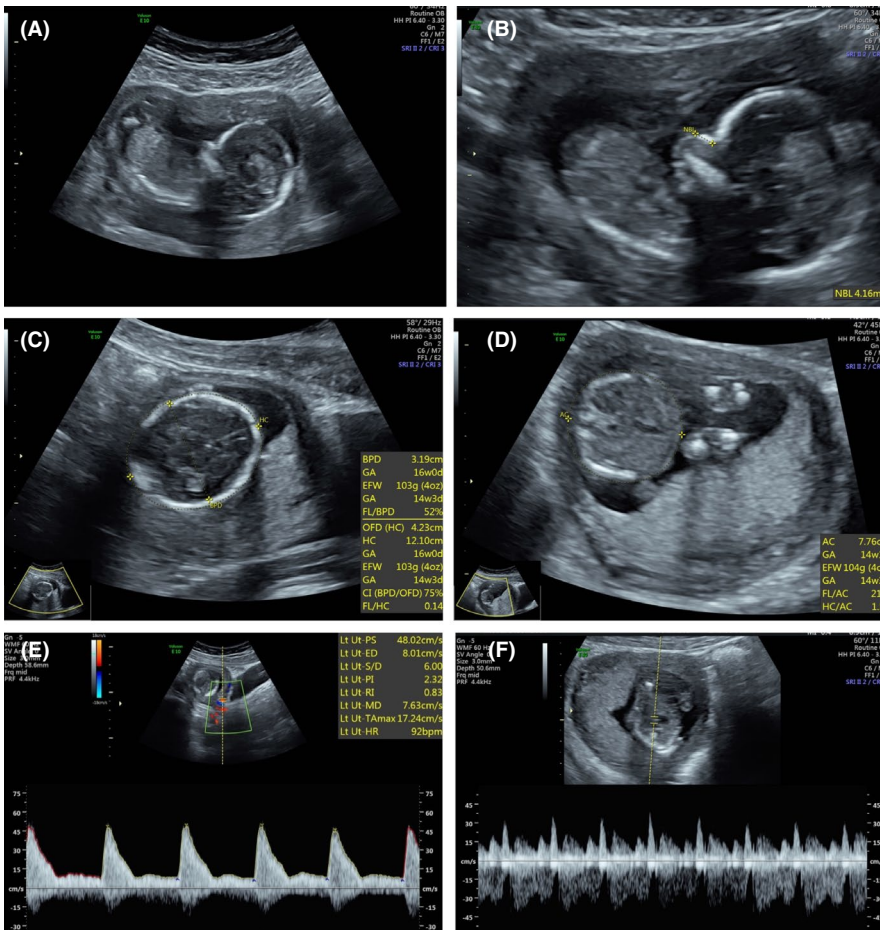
Prenatal 2D sonographic views of the fetus at 16 weeks gestational age. A, Mid-sagittal view of the fetus demonstrating oligohydramnios. B, Facial profile with retrognathia; an anomaly commonly associated with triploidy. C, Cranial measurements appropriate for gestational age. D, Small abdominal circumference in keeping with asymmetric fetal growth restriction. E, Increased maternal uterine artery pulsatility index and notching. F, Abnormal ductus venosus waveform with deep a-wave
